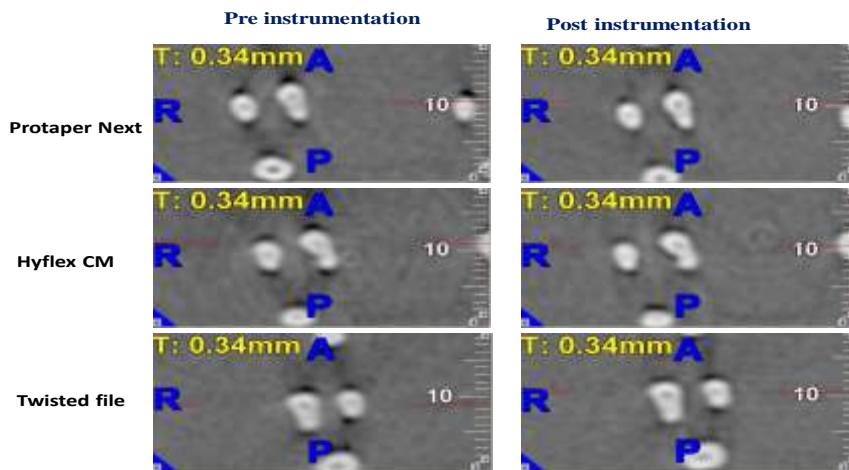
Post instrumentation CBCT(Cross sectional view)
